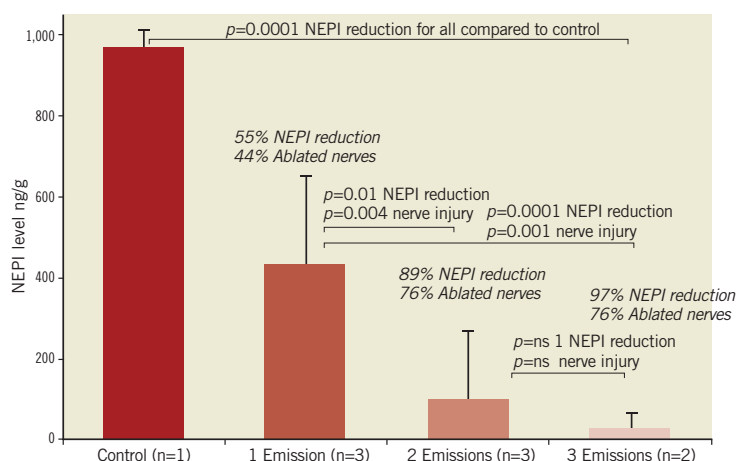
Percent NEPI reduction and percent ablated nerves based on the number of bilateral ultrasound emissions. A) A statistically significant difference was observed in NEPI reduction following one, two or three U/S emissions compared to control. A significant difference was observed between one bilateral U/S emission and two or three emissions. However, there was no difference between two and three bilateral U/S emissions, suggesting a maximum effect of treatment with two emissions. Data presented as mean \pm SD.
